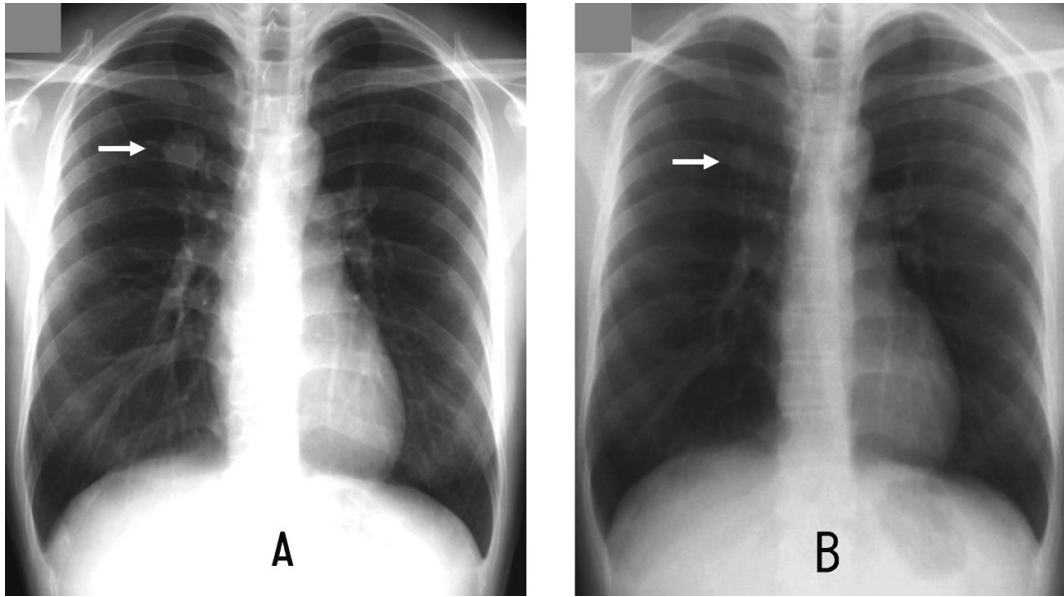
Chest radiograph on admission (A) showing a nodule in the right upper lung field (*arrow*)
